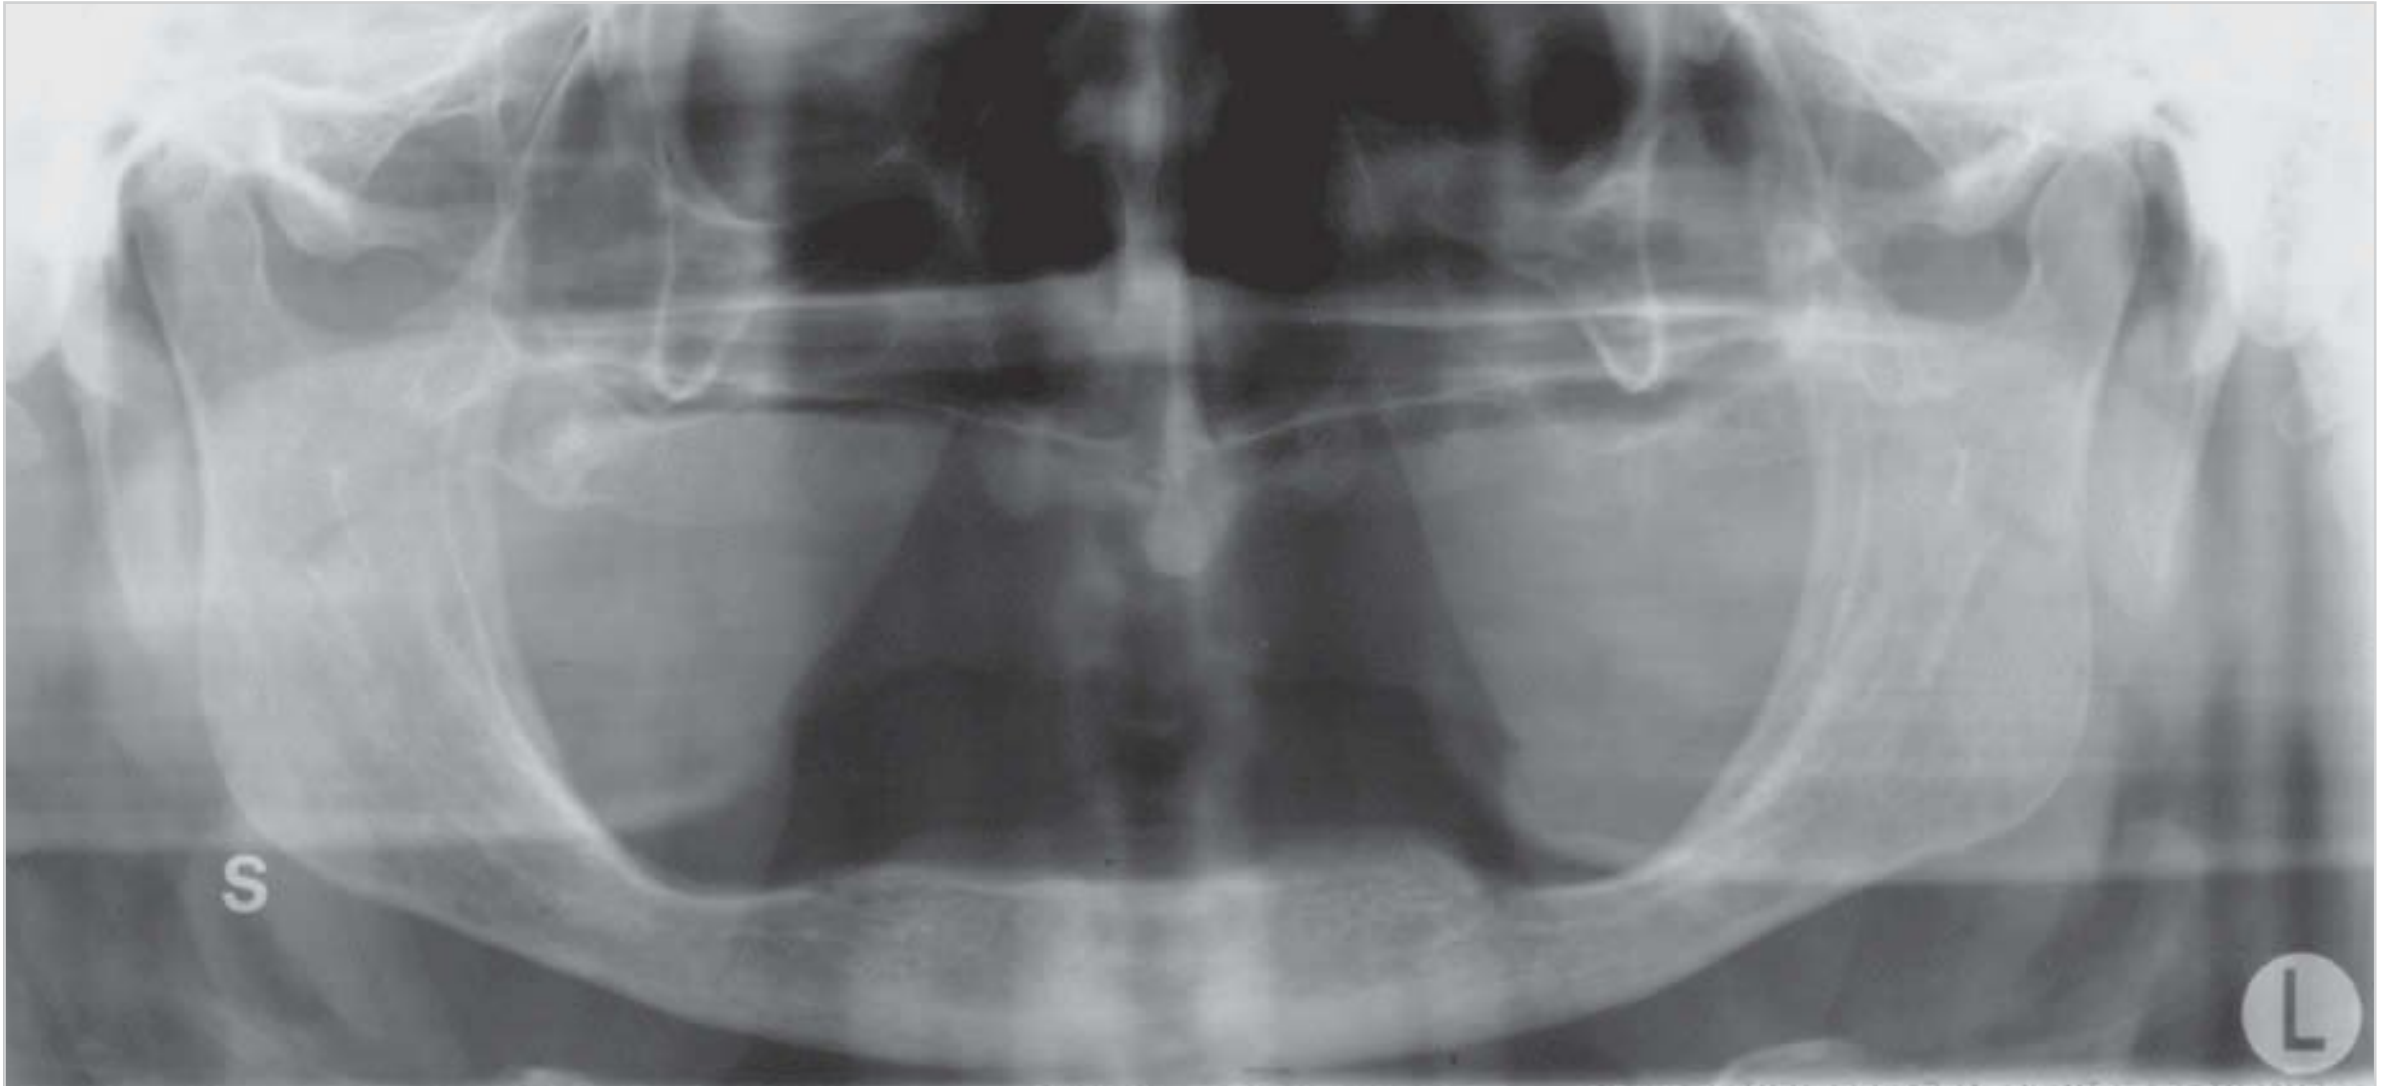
Soft-tissue shadows of the nose and ear lobe on a panoramic radiograph.
